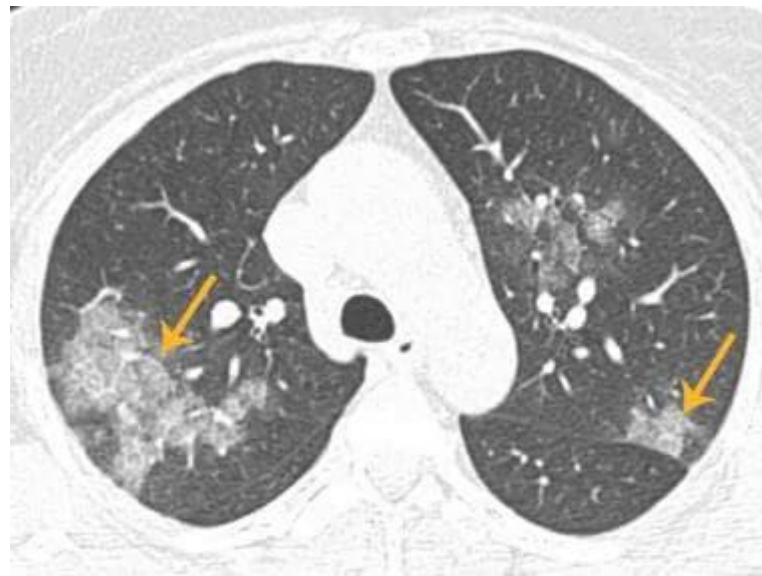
The structure of COVID-19 lung CT images including lung background (black area) and GGO has been shown by yellow arrows as above (Source: <https://images.app.goo.gl/4vDYpZdzhvNvJN1J6>)
